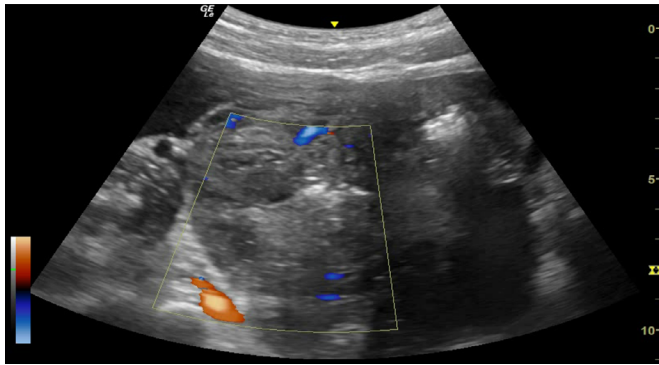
Transvaginal ultrasound performed the day after uterine artery embolisation showing the reduced vascularity of the mass (colour score 2) and hyperechoic spots.
